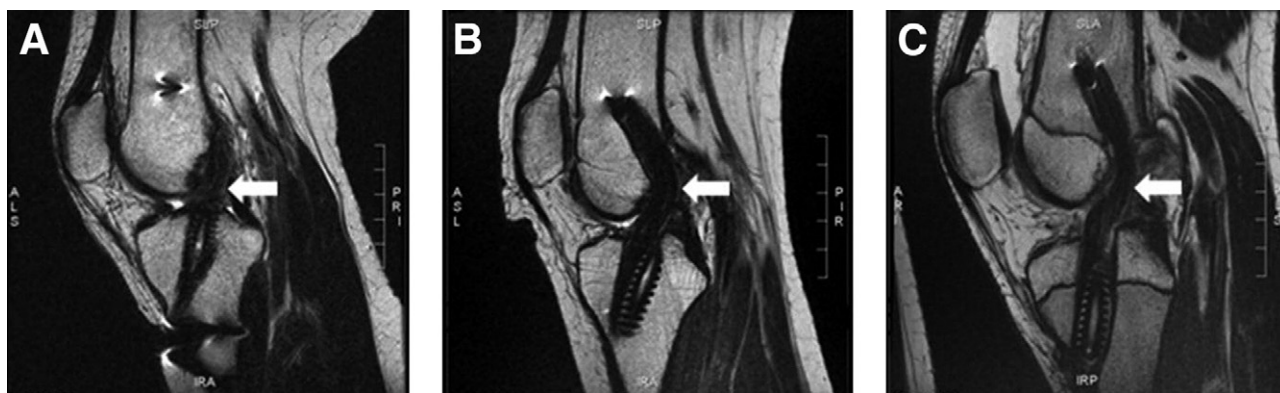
Sagittal MRI sections in T2 sequences 6 months postoperatively. (A) The arrow indicates the disorganized signal pattern in the graft. (B) The arrow indicates the hypointense signal pattern in the graft. (C) The arrow indicates the isointense signal pattern in the graft.
